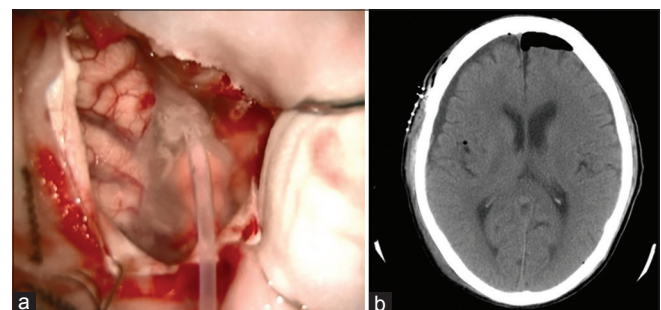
Arachnoid plasty in the transylvian approach (a) Artificial cerebrospinal fluid was injected into the Sylvian fissure through a drainage tube. (b) Brain CT taken a day after operation showing little subdural fluid collection
